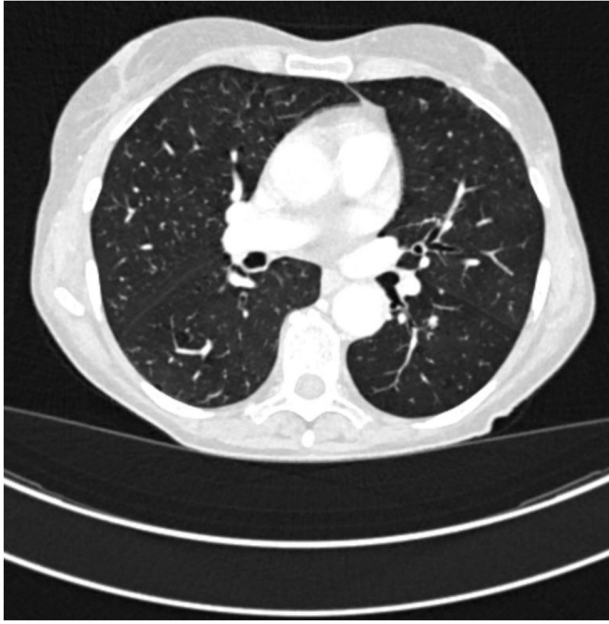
Axial high-resolution computed tomography (HRCT) image showing a solid, 6-mm pulmonary nodule in the perihilar region of the left lower lobe with irregular margins..
